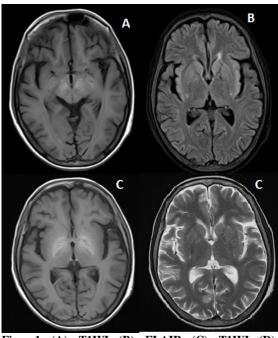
(A): T1WI, (B): FLAIR, (C): T1WI, (D): T2WI.
